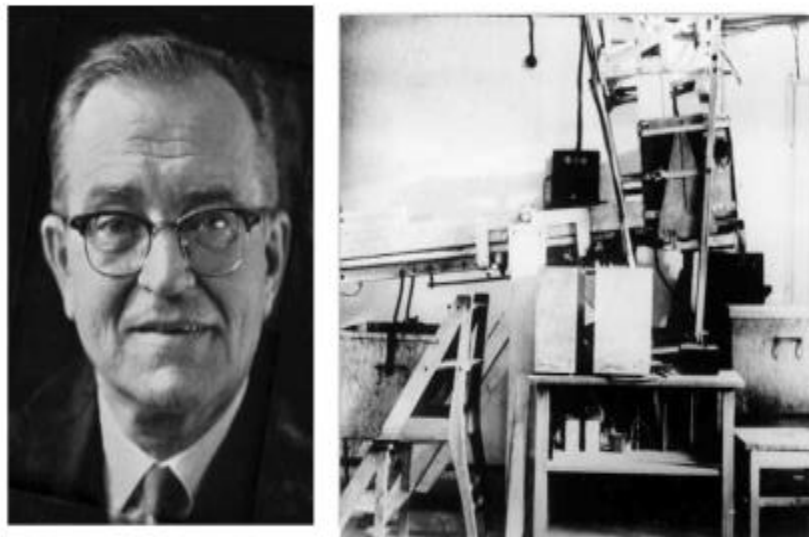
Karl Theodore Dussik and his first medical ultrasound device in 1946 [5].
